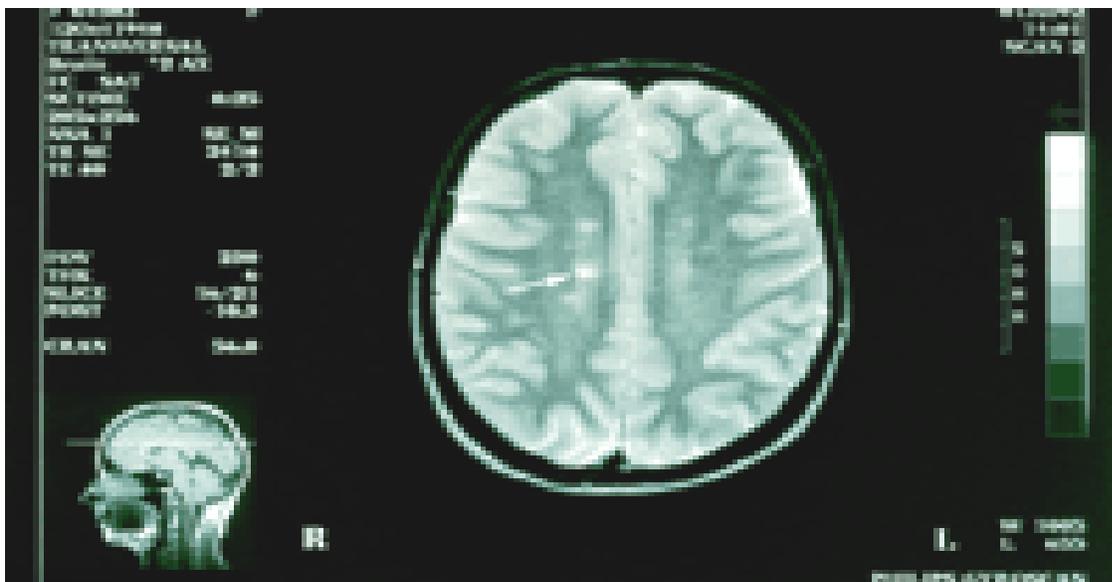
MRI of an MS Patient(6)
